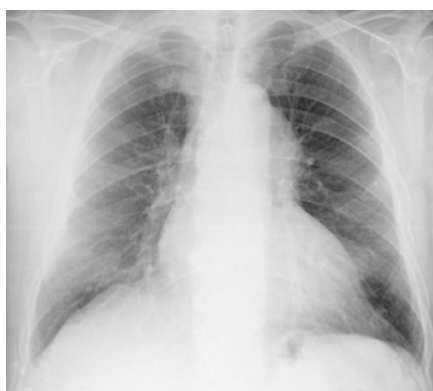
Chest X-ray, showing a slight mediastinal bulge adjacent to the aortic knuckle.
